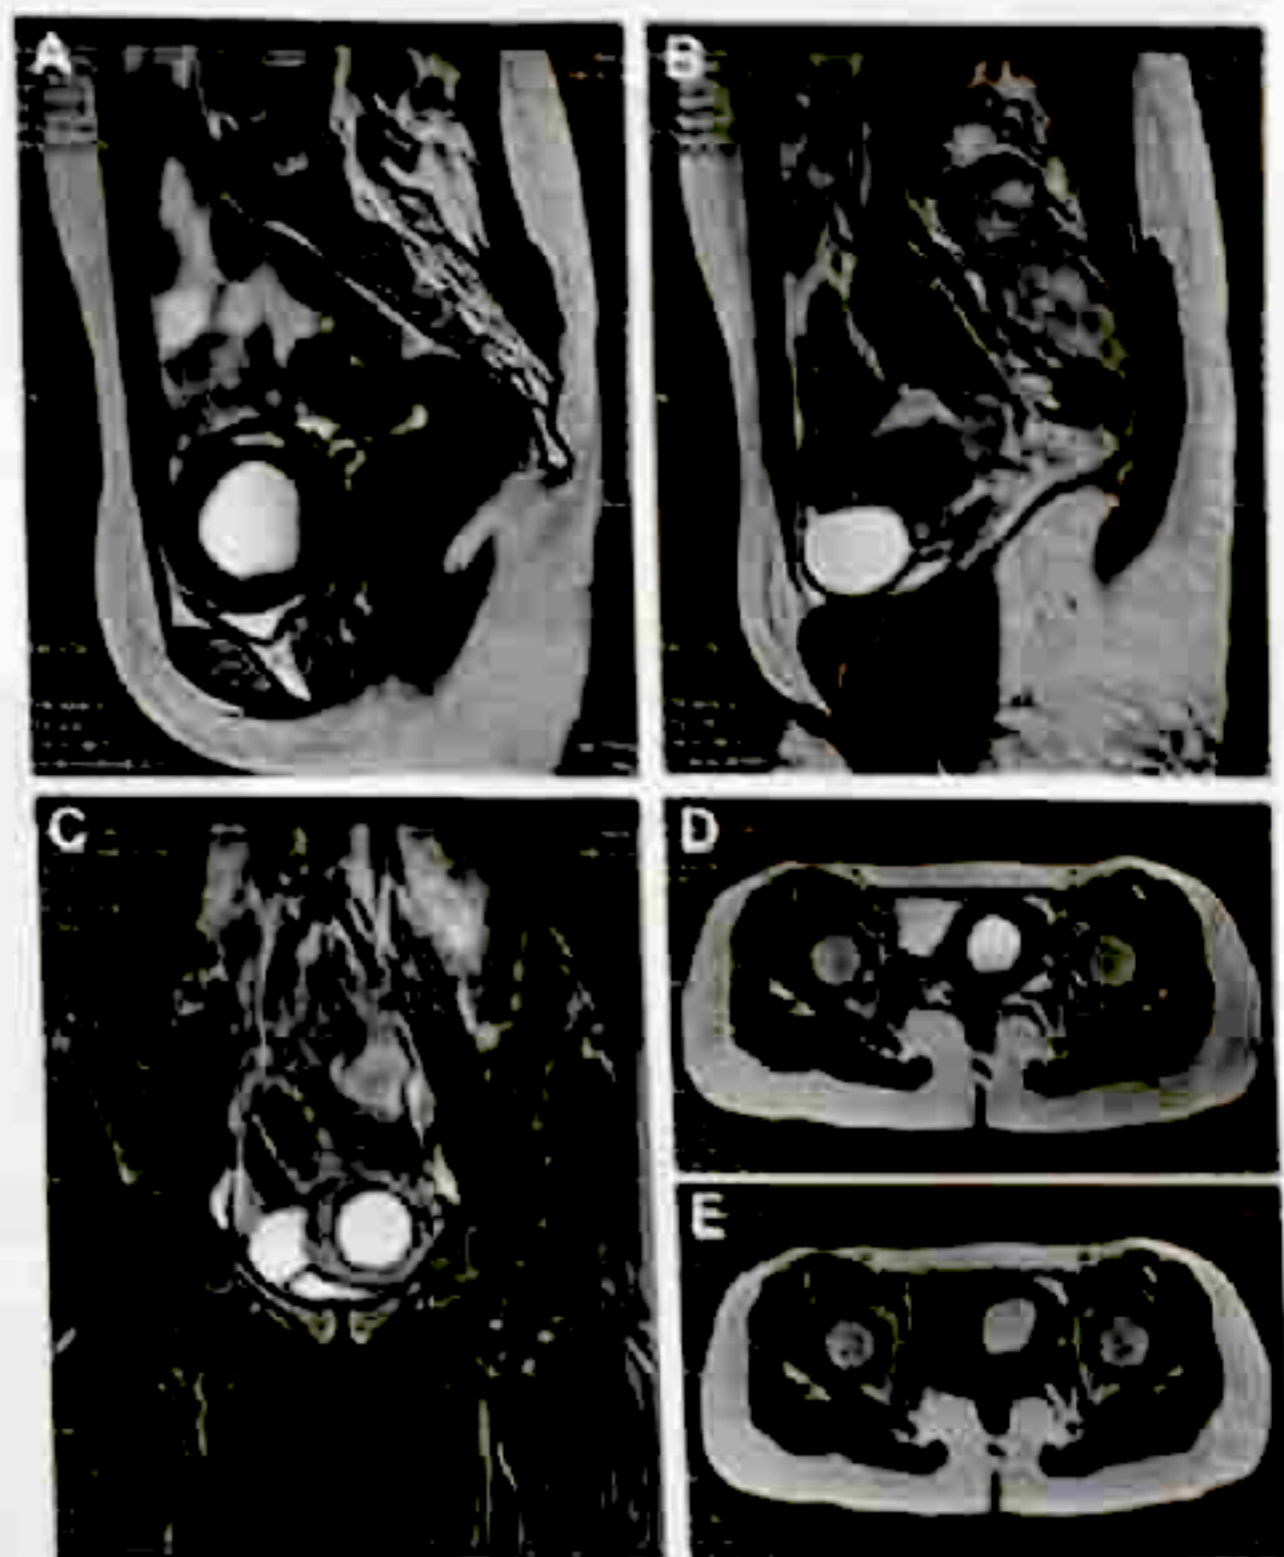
Magnetic resonance imaging of first index patient. A) T2-weight sagittal view showing the hyperintense hematometra. B) T2-weighted sagittal view showing the thin-walled right adnexal cyst. C) T2-weighted coronal view showing the uterus and right adnexal cyst. D-E) T2 and T1-weight transverse view showing the uterus and right adnexal cyst.
